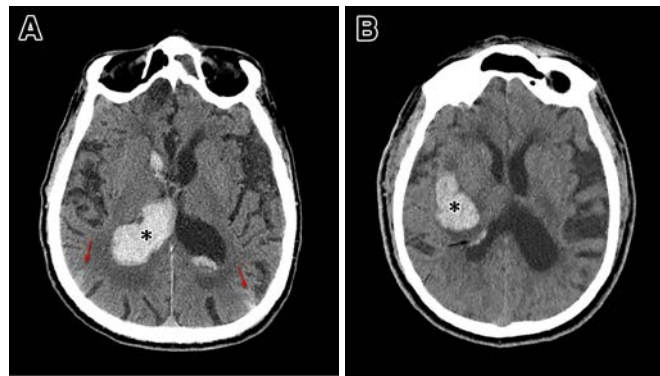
Bilateral intraventricular hemorrhage (asterisk) and subarachnoid hemorrhage (red arrows) (A), as well as a small intraventricular hemorrhage (black arrow) associated with a right parenchymal hemorrhage (asterisk) (B) in axial computed tomography scans.
